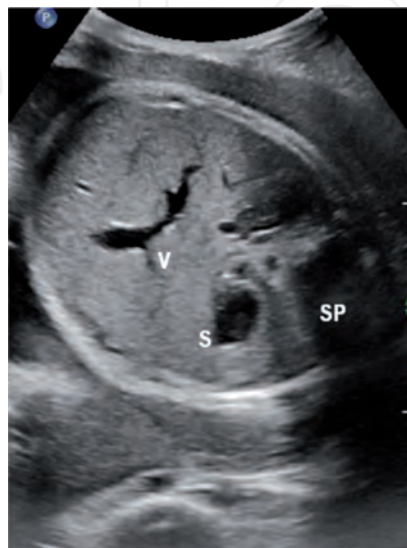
Obstetric ultrasound showing the fetal abdomen. Fetal abdomen: The stomach (S) and intrahepatic portion of the umbilical vein (V) are demonstrated. The spine (SP) is seen posteriorly.*
